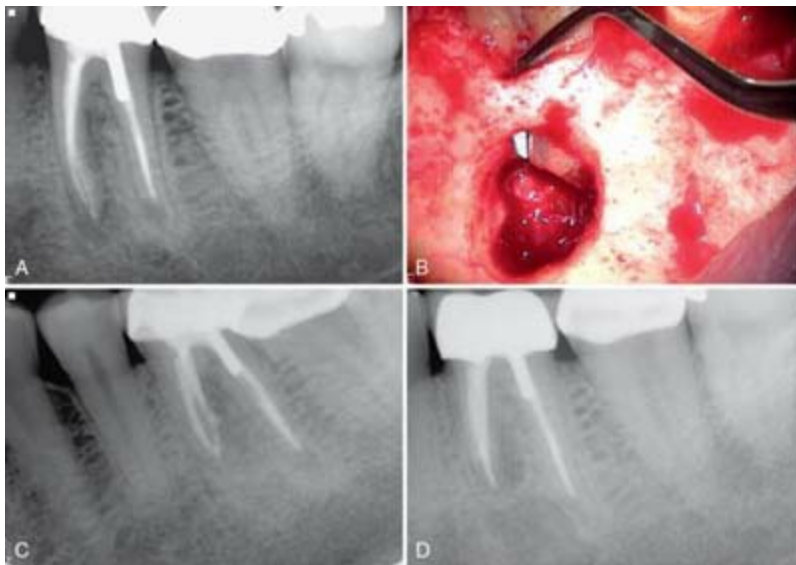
A, Preoperative periapical radiograph of tooth #19. B, Clinical image demonstrating periodontal defect along the facial aspect of the mesial root. C, Immediate postsurgical radiograph. The mesial root end was prepared with ultrasonics and filled with MTA. A mixture of DFDBA and Capsee was placed for guided tissue regeneration. D, One-year follow-up radiograph demonstrating good healing.
